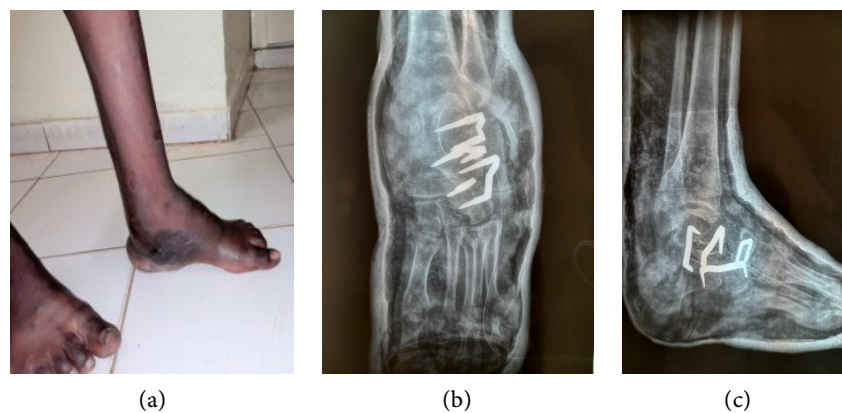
Inveterate paralytic varus equinus foot after surgery ((a): front view; (b): front radiograph; (c): profile radiograph).
